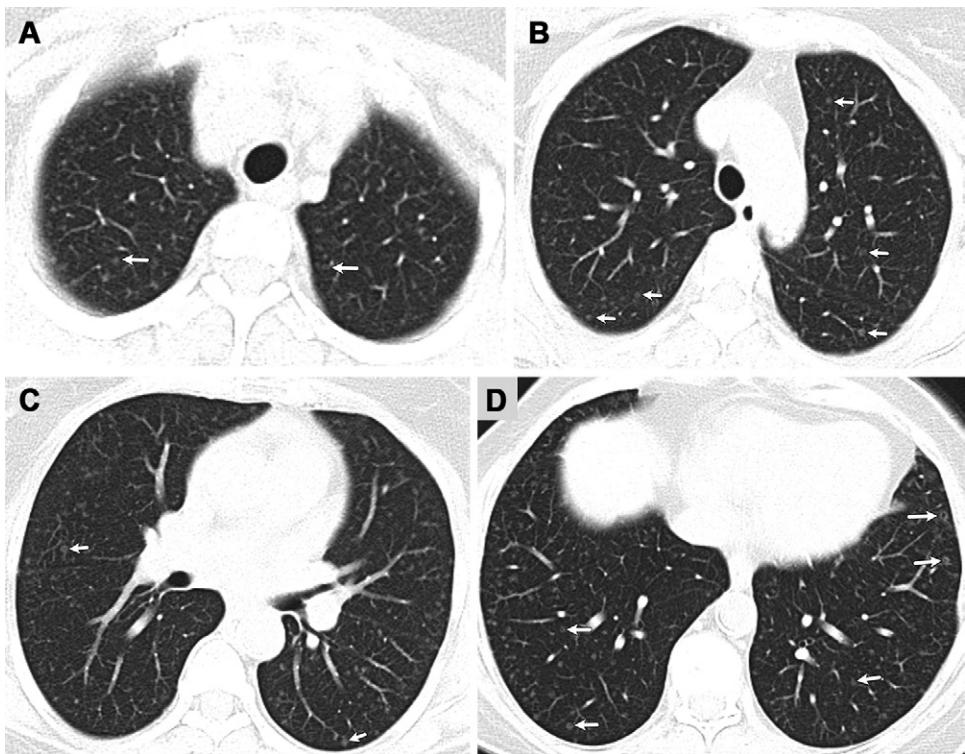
Axial unenhanced chest CT images obtained 5 years before current presentation. Selected images from (A) apices, (B) arcus aorta, (C) lingular bronchus, and (D) basal lung levels using lung window settings ($16 \times 1.5\text{-mm}$ collimation, 120-kV tube voltage, 130-mA tube current, 512×512 matrix, 1.5-mm section thickness). Images were also reconstructed with 1.0-mm section thickness. There are multiple, randomly distributed small (≤ 6 mm) ground-glass nodules. Note that some nodules include central lucencies (ringlike appearance) (arrows).
